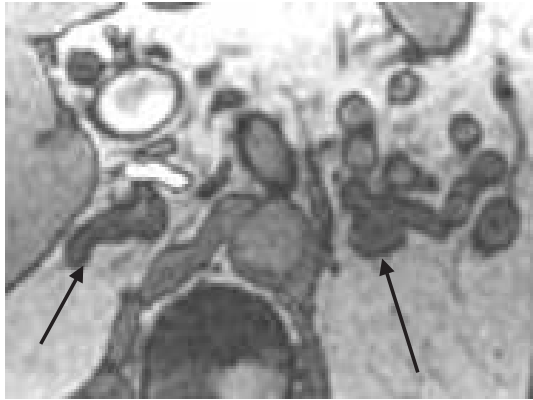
Bilateral adrenal cortical hyperplasia. Axial out-of-phase MR image shows nodular thickening of adrenal glands bilaterally in patient with Cushing's syndrome.
